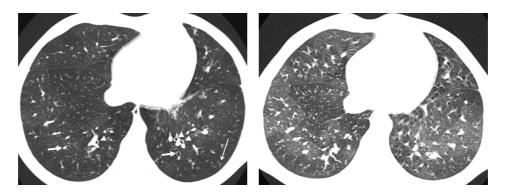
Airway disease on high-resolution computed tomography (HRCT). Eleven-year-old male diagnosed with CVID-like disease; six pneumonias but no CVID-related co-morbidities have been documented. A, Axial HRCT image in inspiration. Arrowheads represent airway with mild wall thickening. Closed arrows represent mild cylindrical bronchiectasis. Open arrow represents small area with tree in bud pattern. B, Axial CT image at end expiration. At both sides, areas with air trapping are visible as lucent areas.
